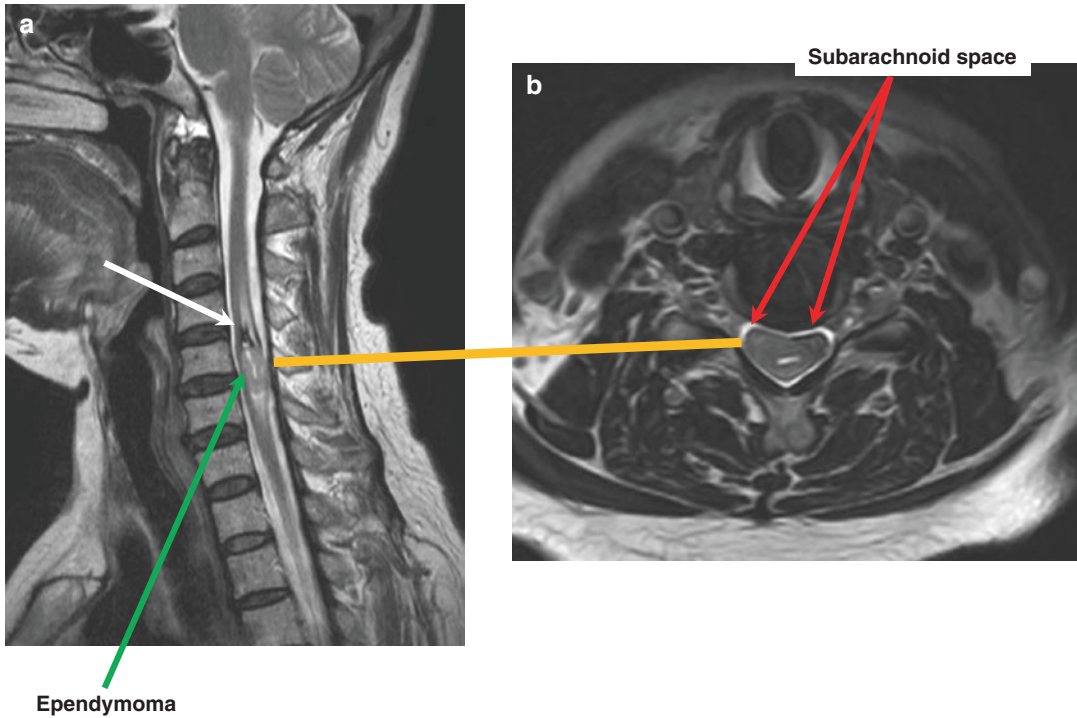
Intraductal ependymoma at C5–C6 spinal level (*green arrow*) in a 37-year-old female. (a) The sagittal T2-weighted MR image shows a 1.5 cm well-defined intramedullary mass with surrounding cord edema and hemosiderin deposition (“hemosiderin cap”) at its cranial
